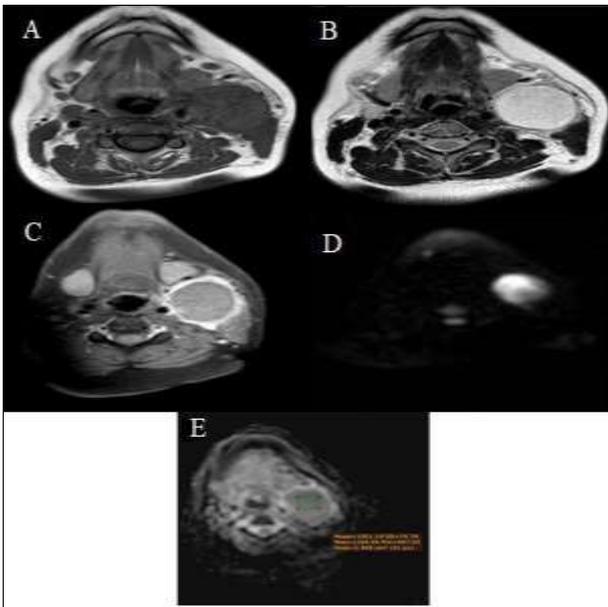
MRI findings: (A) a Well-defined cystic lesion at left carotid Space appear low signal intensity at T₁WI, (B) high signal intensity at T₂WI, (C) thick marginal enhancement at post contrast fat suppressed T₁WI, (D) seen restricted on DWI, (E) with ADC value estimated to be $1.051 \times 10^{-3} \text{ mm}^2/\text{s}$ (E)
